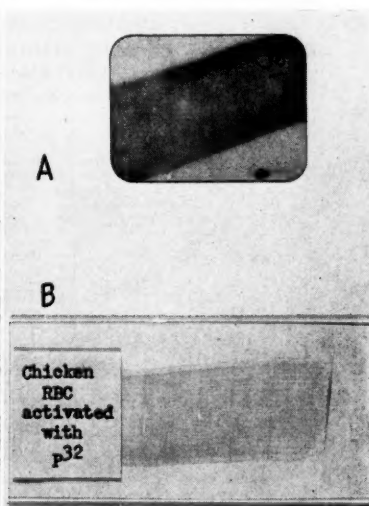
(A) Radioautograph, on x-ray film of (B) thin smear of P³² tagged chicken erythrocytes.
